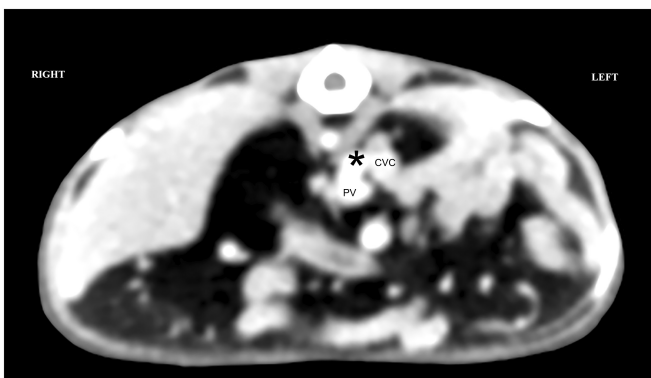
Transverse CT image of the abdomen at the level of the shunting vessel (*) entering the caudal vena cava (soft tissue setting, venous phase postcontrast). The portal vein is noted right lateroventral to this vessel
